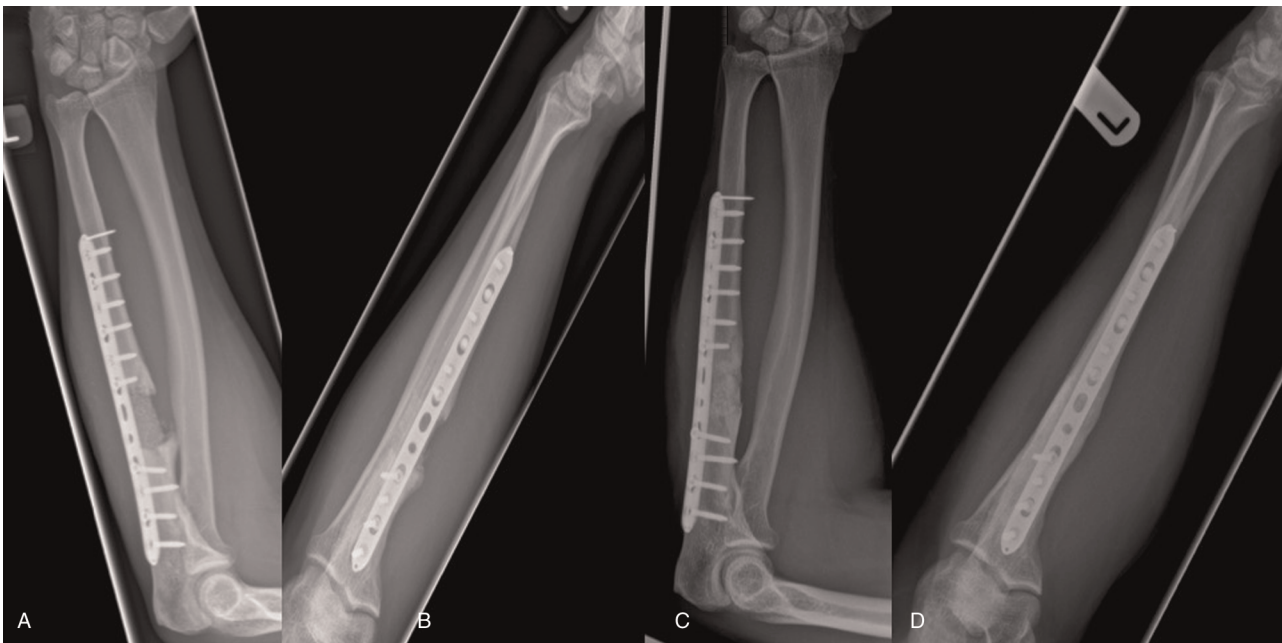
(A) AP and (B) lateral postoperative radiographs after second stage of Masquelet technique (6 weeks from first stage) demonstrating removal of cement spacer and autologous bone grafting to the defect area. (C) AP and (D) lateral postoperative radiographs 4 months later showing osseous healing of the bone defect area.
